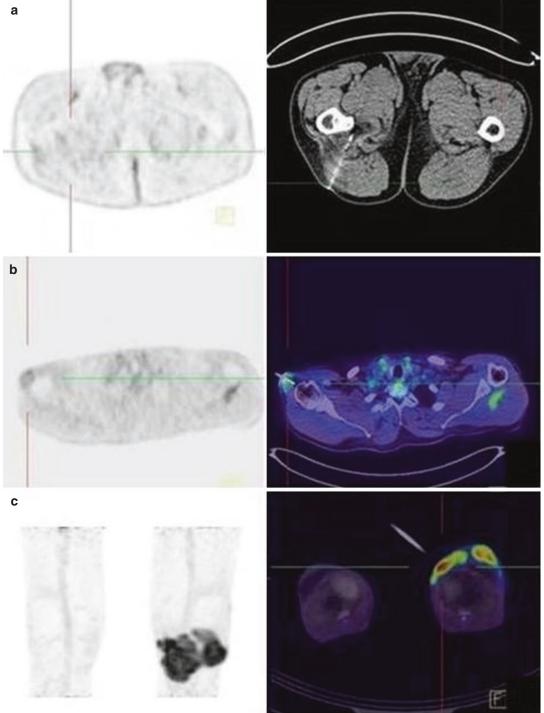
¹⁸F-FDG accumulates in the cells in proportion to the rate of glucose metabolism, giving information on biological activity of the tumoral parts, and subsequent the identification of intratumoral heterogeneity, reflected as areas of high and low SUV. By identifying the most metabolically active portion of a tumor mass, nuclear medicine techniques can guide a biopsy to a site most likely to
